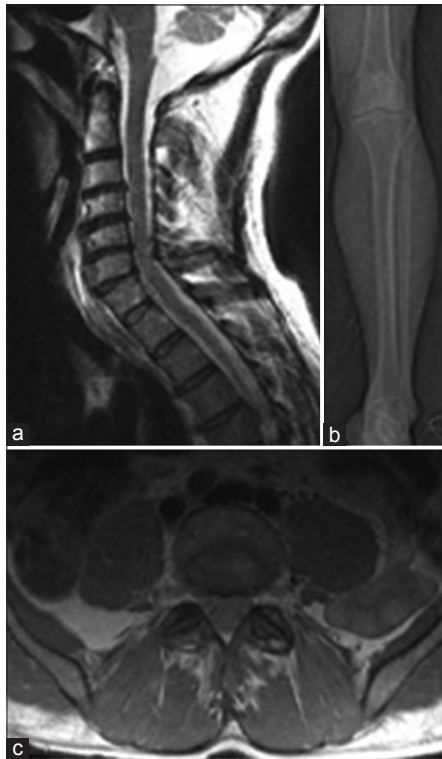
(a) Sagittal T2-weighted magnetic resonance imaging (MRI) showing degenerative spondylosis without significant cord compression. (b) Computed tomography scout image of left leg demonstrating fibular head without evidence of fracture. (c) Axial proton-density-weighted turbo spin echo MRI showing the L5 nerve roots exiting the spinal canal, no foraminal stenosis, or disc herniation
